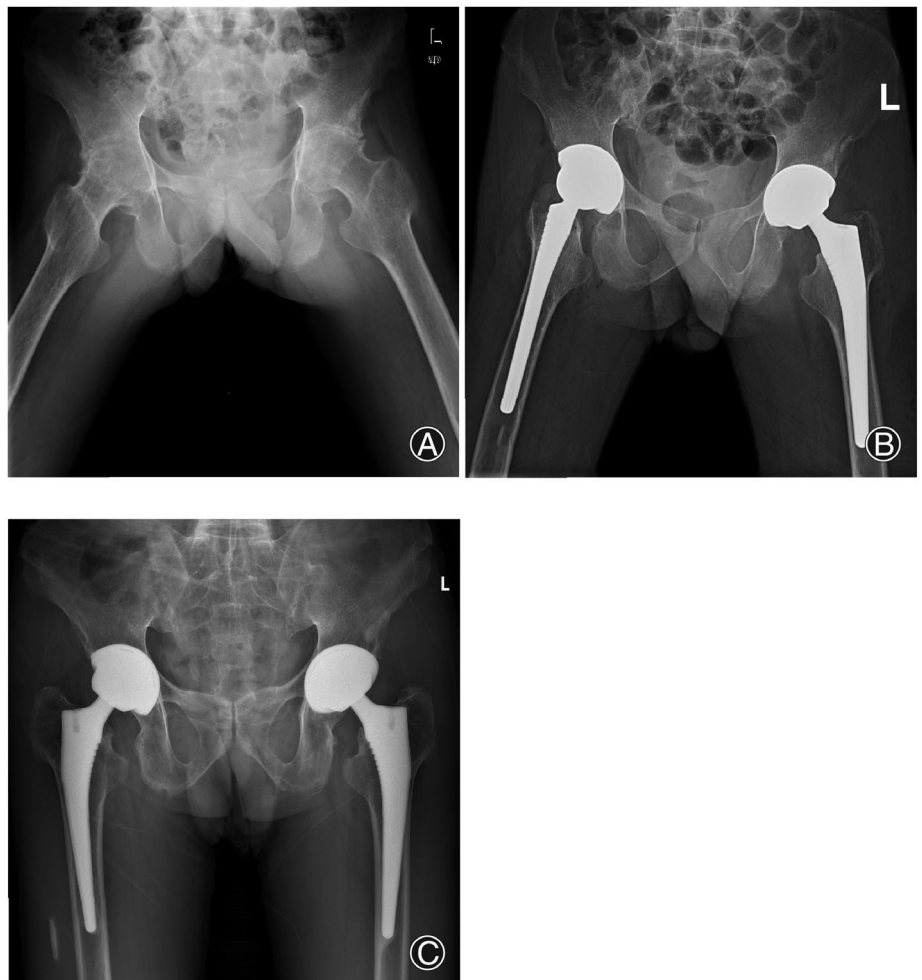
Preoperative (A), postoperative (B), and postoperative 10 years (C) radiographs of a 31-year-old male AS patient, who had bilateral hip ankylosis at a position of 30° flexion, 25° abduction, and 15° external rotation before THA (A). The right hip still had a certain degree of external rotation the next day after THA (B), and the external rotation had been completely corrected at 10-year follow-up (C).
